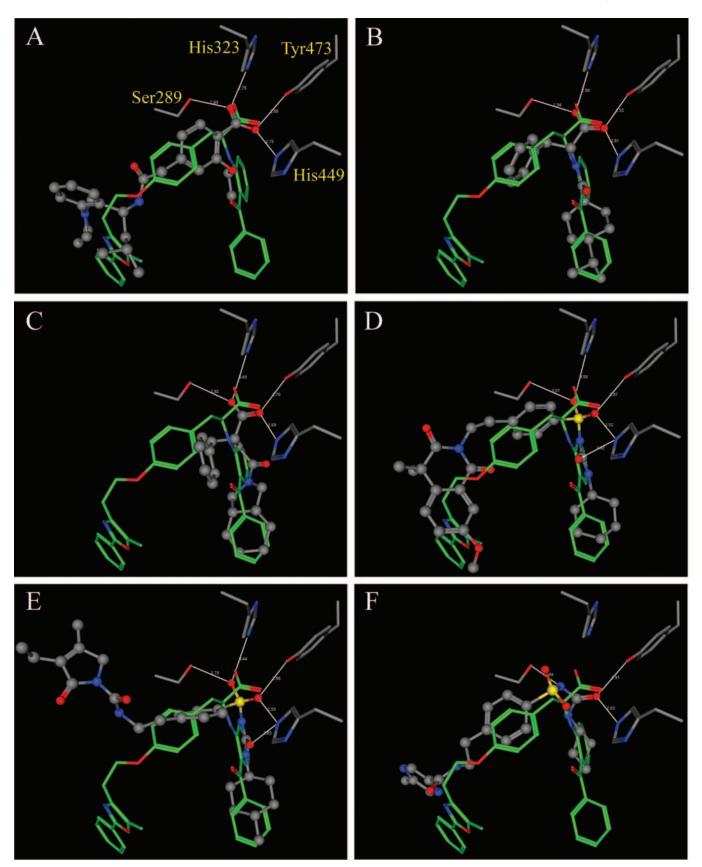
Three-dimensional structures of three glinides and three sulfonylureas docked to PPAR $\gamma$ . Repaglinide (A), nateglinide (B), mitiglinide (C), gliquidone (D), glimepiride (E), and glipizide (F) (gray ball and stick models) docked to PPAR $\gamma$  and superimposed to the farglitazar complex X-ray structure (green stick model). Of PPAR $\gamma$ , only the side chains of His323, His449, Ser289, and Tyr473 are shown (gray stick models). Compounds were docked into the PPAR $\gamma$  binding site using the AutoDock software. For each ligand, the figure reports the best docked pose. For details on pose selection, see *Materials and Methods*.
